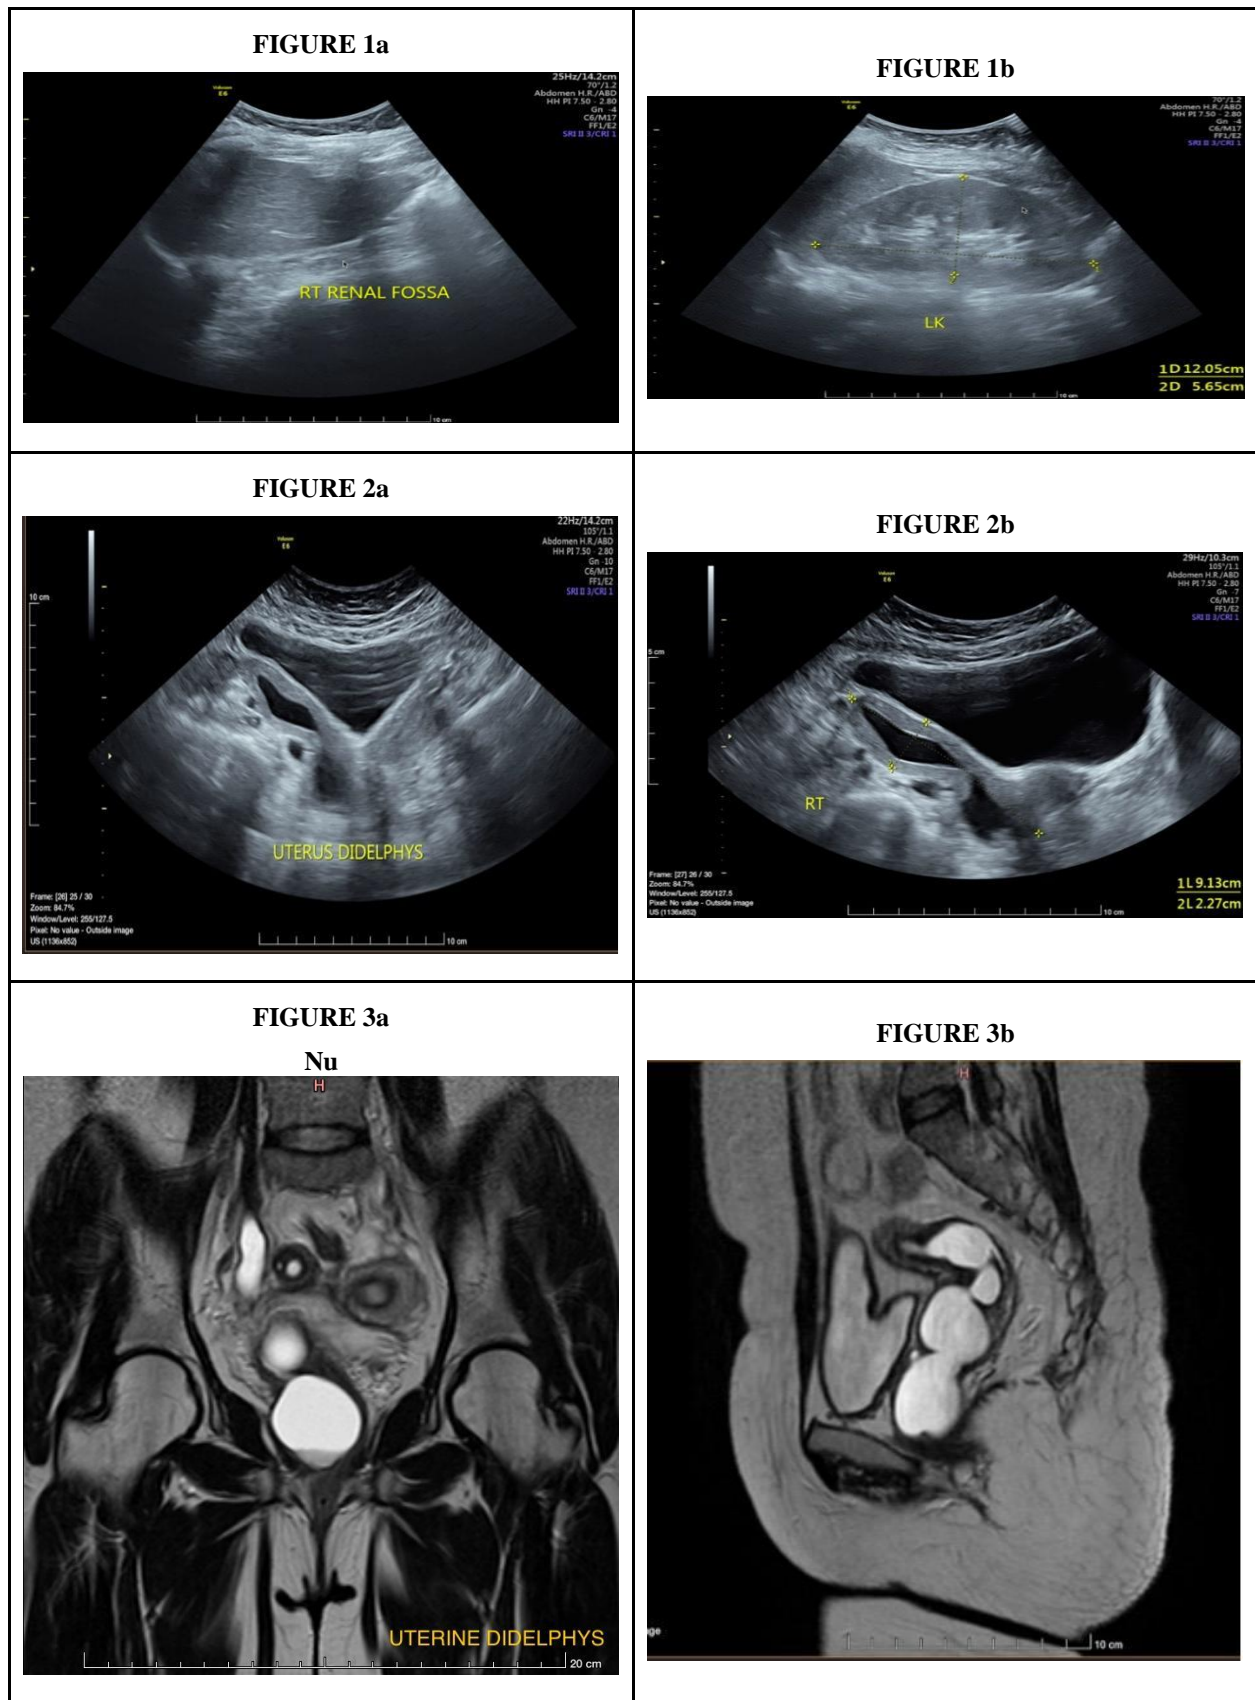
USG images; Figure 3a-3b: MRI images.
